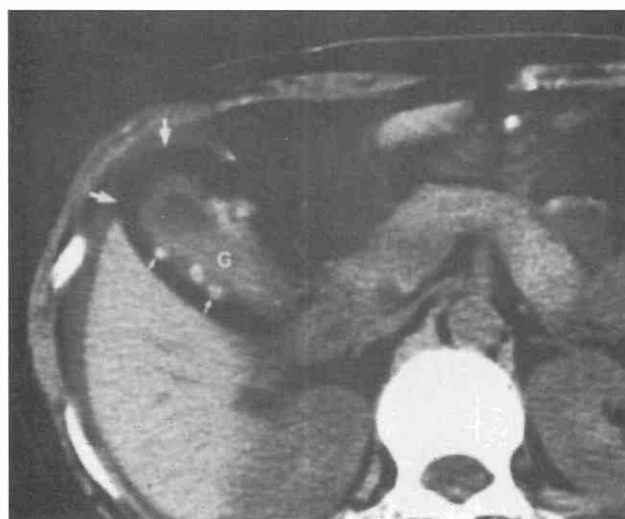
Adenomyomatosis with proliferation of subserosal fat (large arrows), intramural diverticula containing stones (small arrows), and soft tissue mass (G) in gallbladder lumen. (From Miyake H, Aikawa H, Hori Y, et al: Adenomyomatosis of the gallbladder with subserosal fatty proliferation. CT findings in two cases. *Gastrointest Radiol* 17:21, 1992.)
